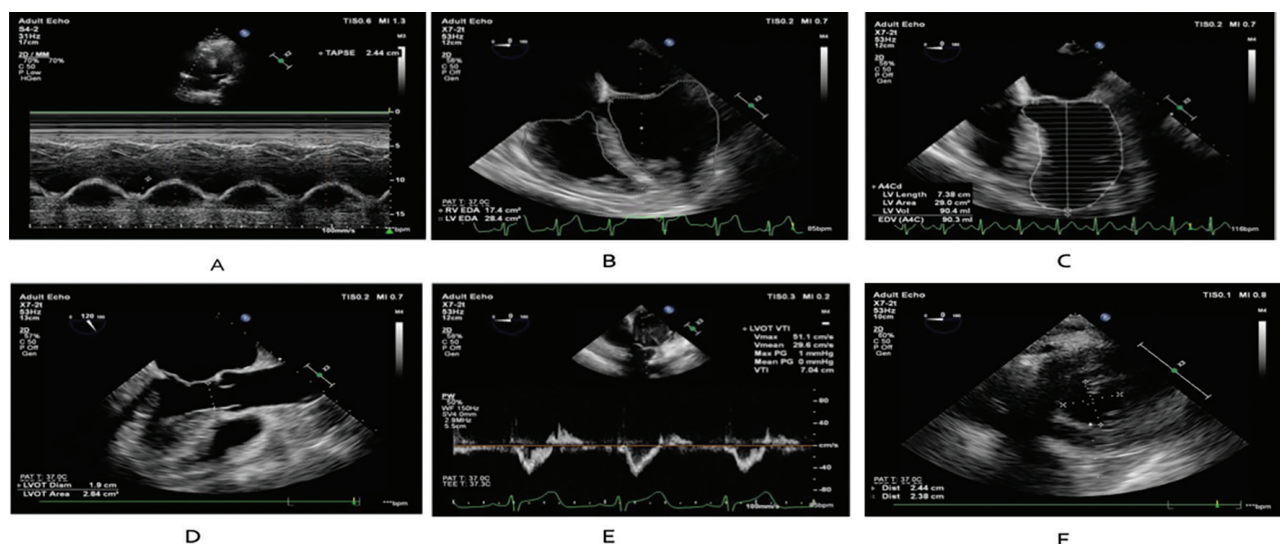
Transthoracic and transesophageal measurements
